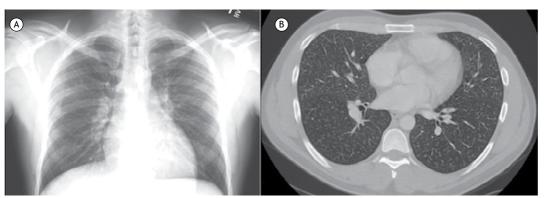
In A, a chest X-ray showing micronodular shadows. In B, a CT scan of the chest, showing centrilobular nodules in both lung fields.
